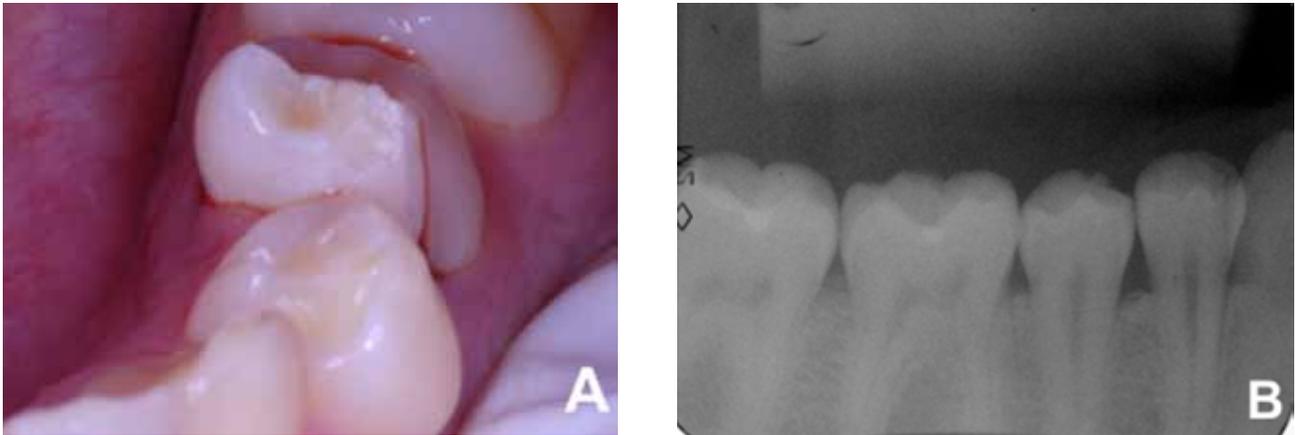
Initial clinical and radiographic examination of tooth 35. A - Clinical aspect of the fragment slightly shifted. B - Radiographic image.
